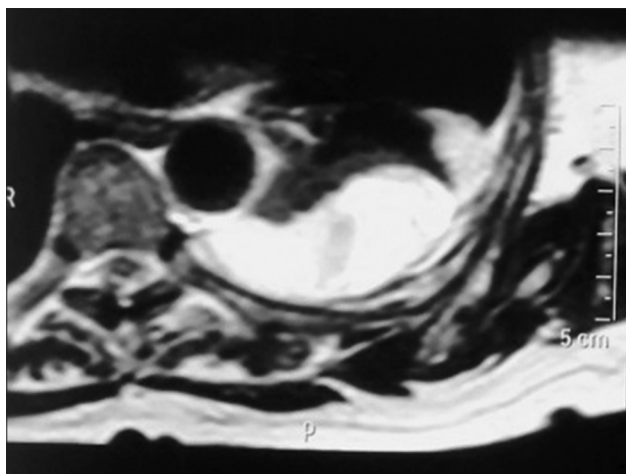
Immediate postoperative T2-weighted image showing complete tumor excision. There is some fluid collection in the tumor bed
